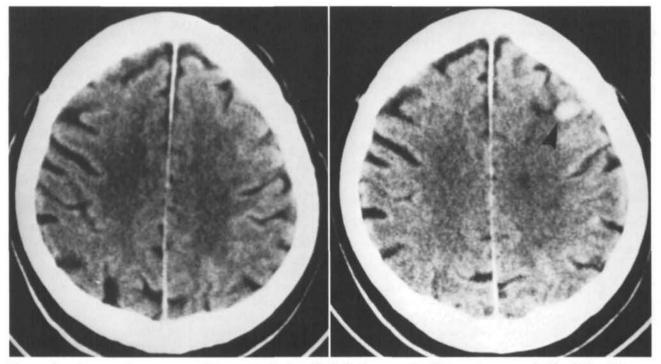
Computed tomograms (CT scans) in Patient 98. Left: Preoperative CT scan is unremarkable. Right: CT scan after carotid endarterectomy without intraluminal shunt shows small left cortical hemorrhage at gray-white matter junction (arrowhead).
